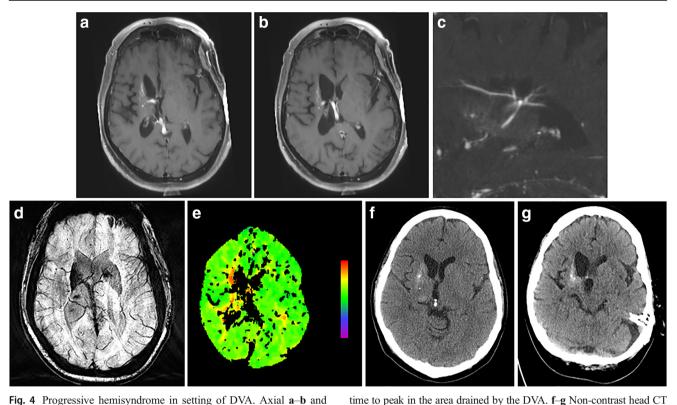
Progressive hemisyndrome in setting of DVA. Axial \mathbf{a} - \mathbf{b} and sagittal T1-weighted gadolinium enhanced images demonstrating a DVA with radicles originating in the right corona radiata and basal ganglia. d Increased T2-star signal in the right basal ganglia suggestive of venous congestion. e CT perfusion study demonstrating subtle increased
